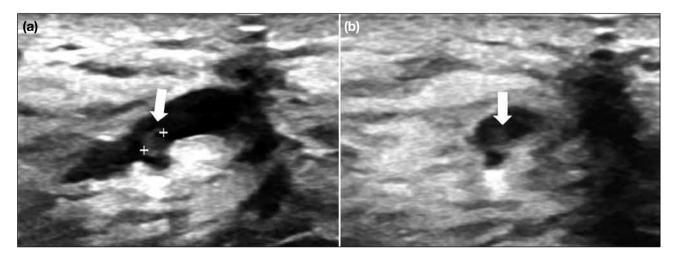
A 25-year-old female presented with left nipple discharge. (a) Transverse plane. (b) Longitudinal plane. Ultrasound shows a dilated central mammary duct (arrows) in the left breast periareolar region at 4 o'clock position associated with intraductal soft tissue nodule. Subsequent biopsy confirmed intraductal papilloma.
